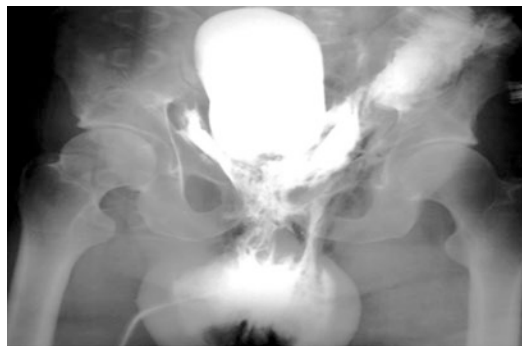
Plain film cystogram reveals extraperitoneal bladder rupture with extravasation into the scrotum. Surgical exploration revealed anterior bladder neck and prostatic urethral laceration
